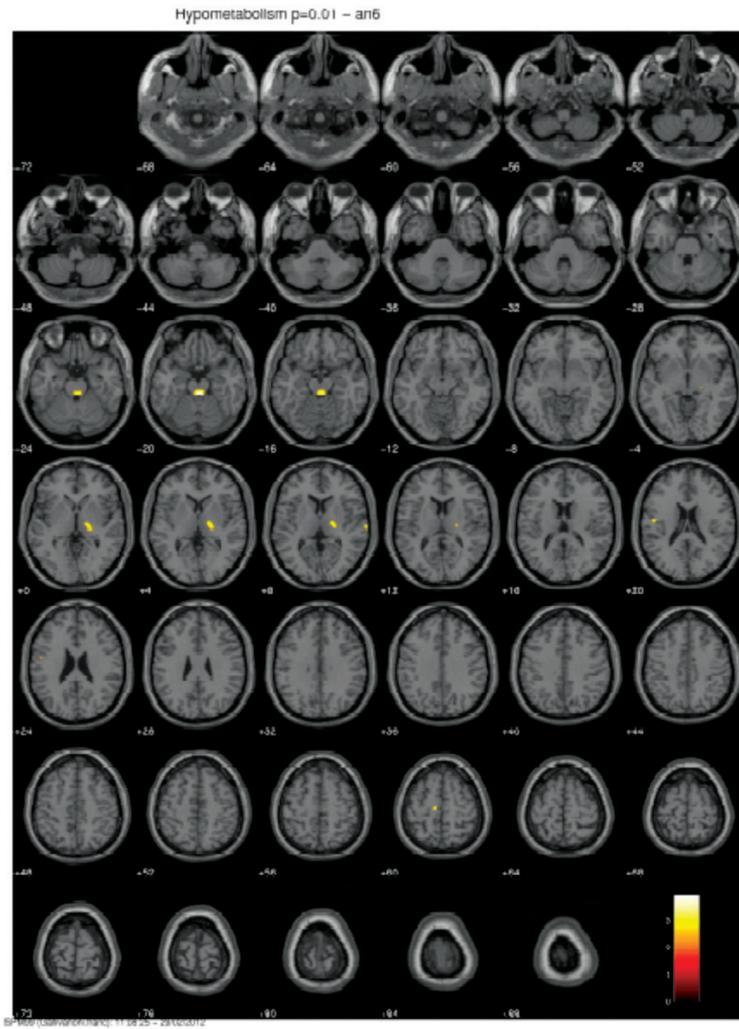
Template of Normal MRI
